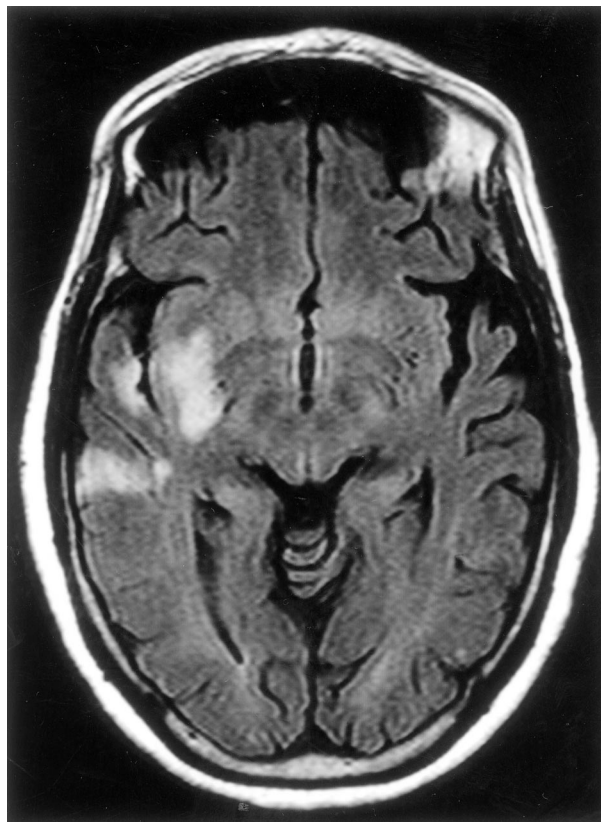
Magnetic resonance imaging showing acute infarctions in the right temporal lobe and internal capsule. Cerebellar and basal ganglia infarctions are not depicted on this image.
